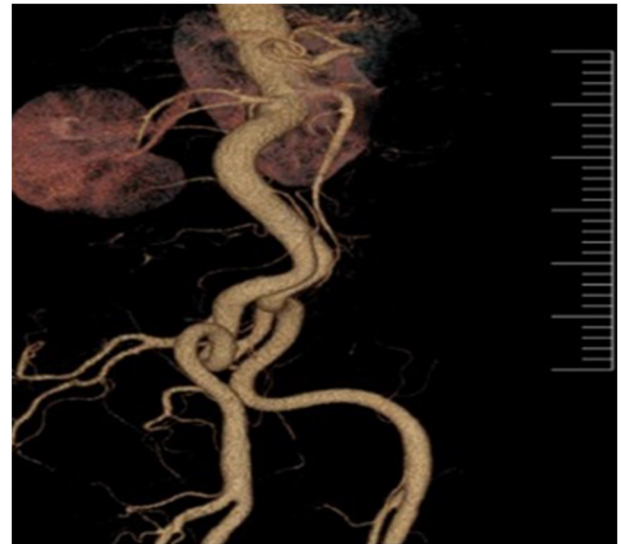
Computed tomography angiography. There was no abnormality of the mesenteric artery.
